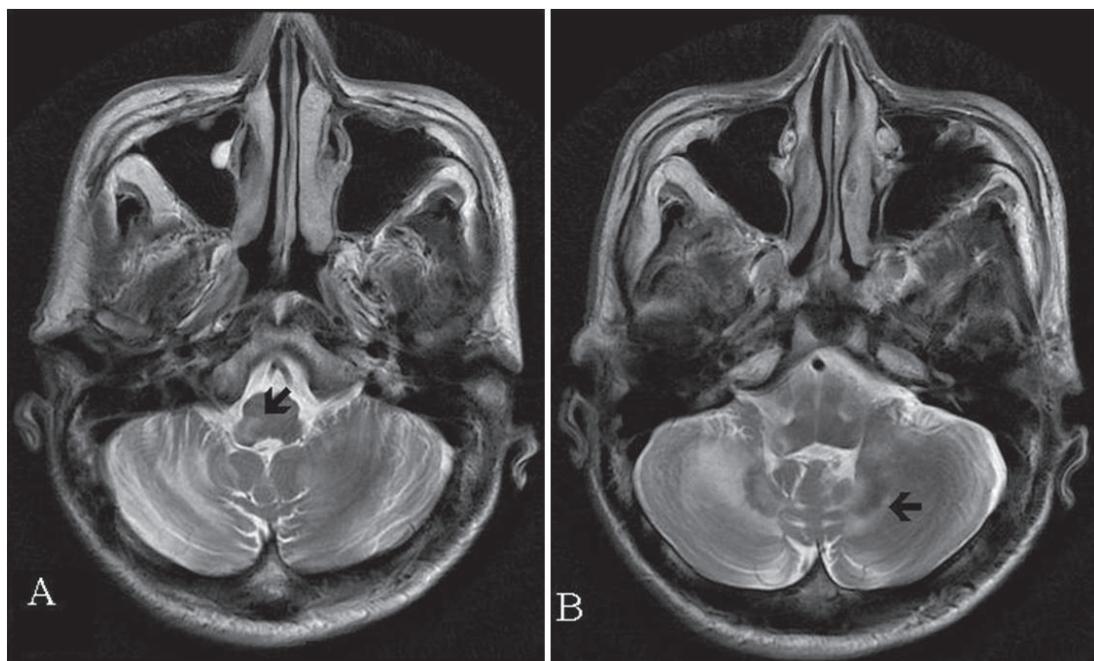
Follow up MRI (3 Tesla) examination at 5 weeks post HAART therapy. Axial T2-weighted images (TR/TE 6000ms/126.9ms). Arrows showing new high signal intensity lesions at the right side of medulla (A) and in the left cerebellum (B).
